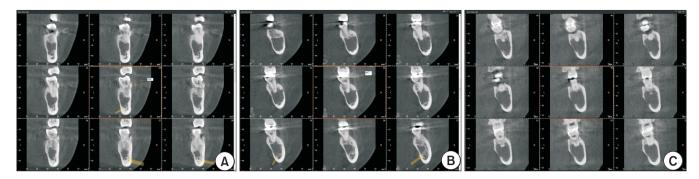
Cone-beam computed tomography of different degrees of bone thinning pattern. A. Mild cortical bone thinning. B. Moderate cortical bone thinning. C. Severe cortical bone thinning.
